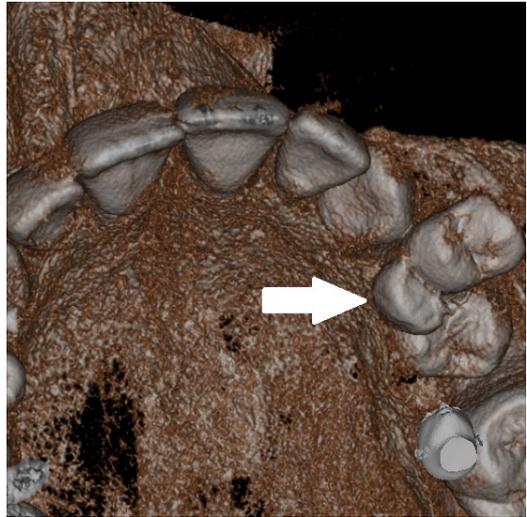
The reconstructed 3D CBCT image of the related area in axial plane (The abnormal structure was shown with a white arrow).
